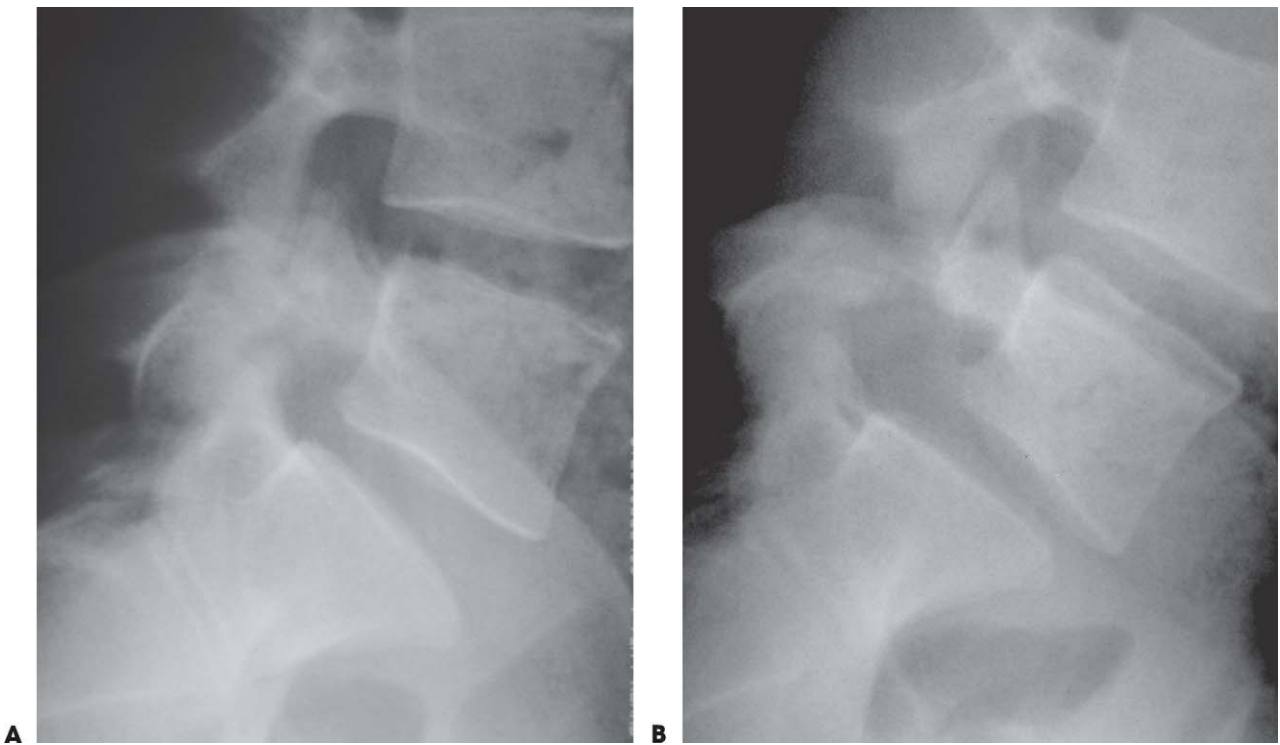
A and B. Traction (A) and compression (B) radiographic views of an L5 spondylolysis demonstrate significant instability. L5 translates anteriorly approximately 25% with a compressive load.
